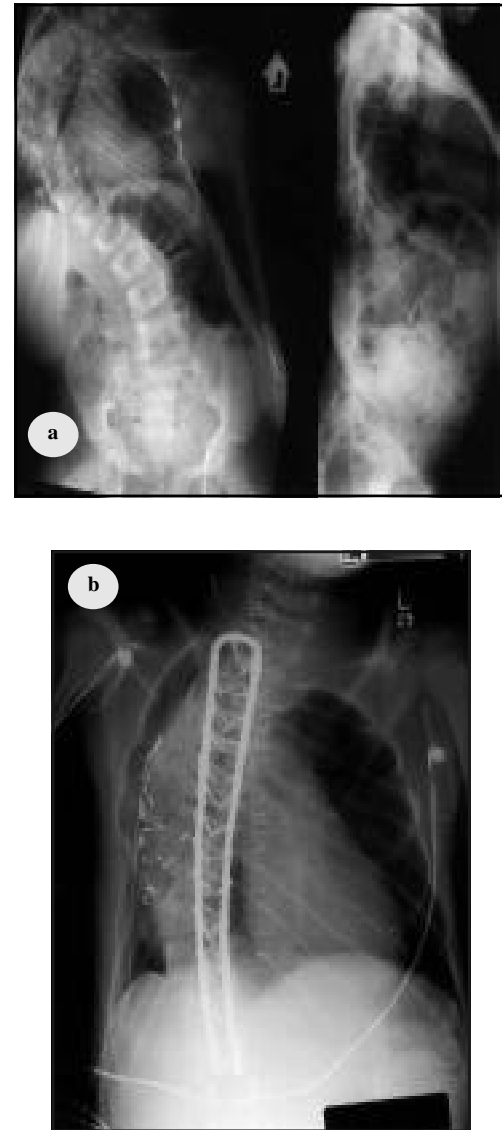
X-ray showing the a) thoracolumbar spine (T-L) anteroposterior and lateral of patient with idiopathic scoliosis showing marked S-shaped scoliosis with a main curve in mid thoracic area, convexity to the right, with an angle of approximately 100 degrees. There is smaller L convex cervical and lumbar curve. There is lack of normal kyphosis and lordosis within T-L spines in the lateral position as seen by a straight spine. b) Patient's anteroposterior and lateral with idiopathic scoliosis (same patient as in Figure 1a) showing status post spinal fusion, with endotracheal tube and internal jugular line in the proper place. Marked straightening of the severe scoliosis. T - thoraco, L - lumbar
